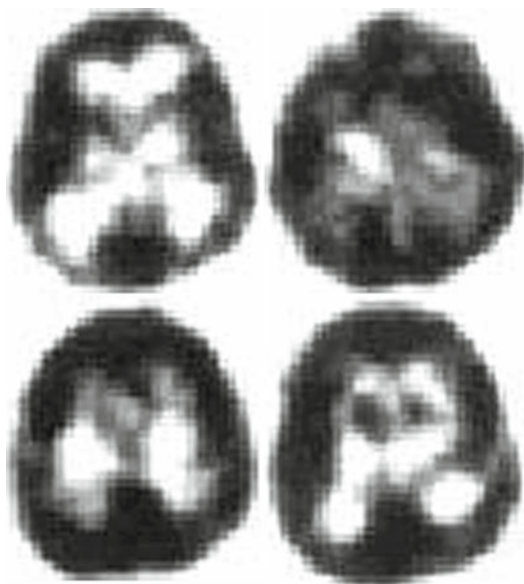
Early whole-brain tomographic FDG images of brain function in a normal volunteer reveal high concentration of the agent in cortical and subcortical grey matter. The brain images were obtained with positron computed tomography (PCT)
